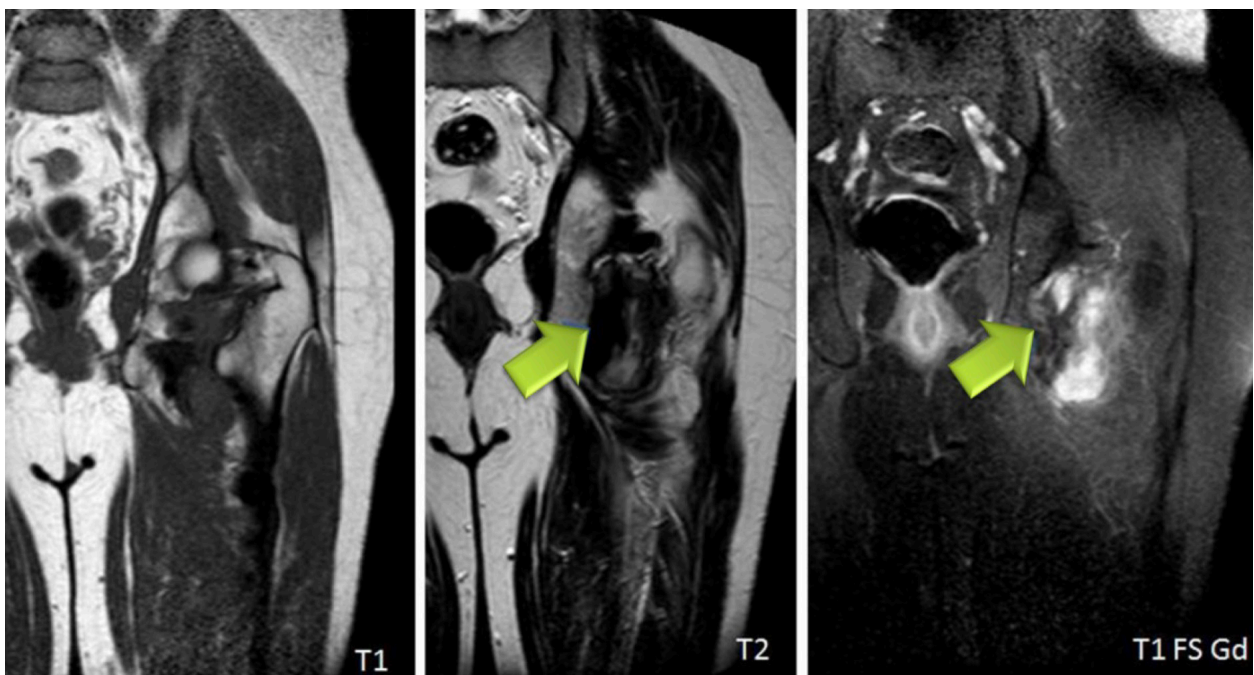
Aggressive fibromatosis of the left upper thigh in a 44-year-old female. MR images showing an infiltrative heterogeneous lesion with areas of low signal intensity in all pulse sequences (arrows). Following gadolinium administration these collagenized bands demonstrate lack of enhancement.
